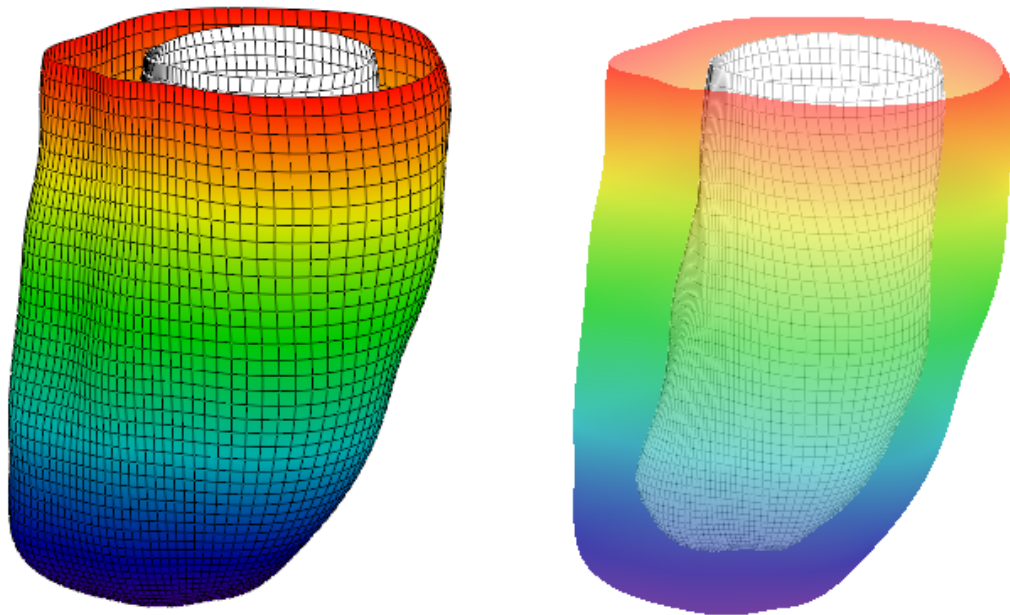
Epicardial and endocardial surfaces of the model that was constructed based on DT-MRI data. On the left, the epicardium is opaque. On the right, the epicardium is semi-transparent. Colour shows z-coordinates.
